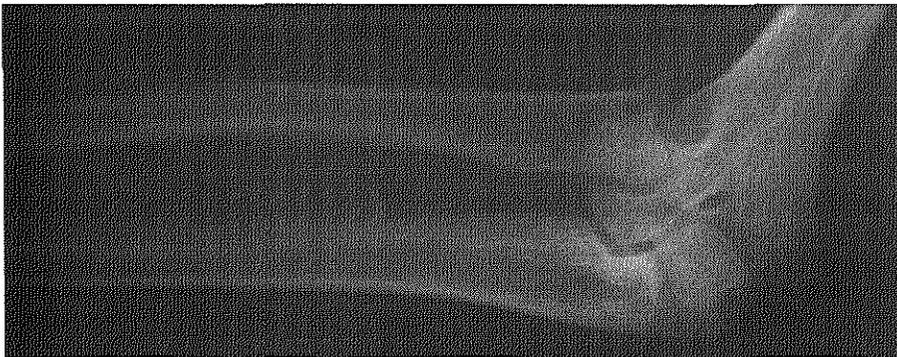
X-ray of the right elbow of member III:2 of family 1 at age 13 revealing a dysplastic elbow joint.
